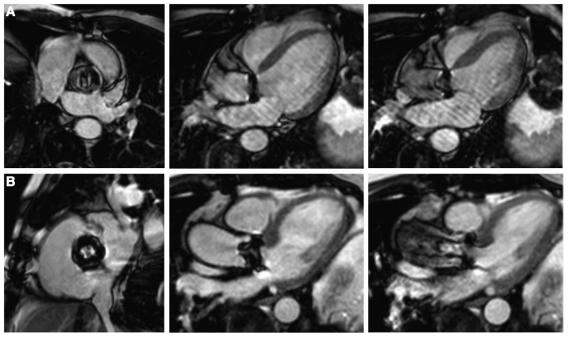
Magnetic resonance imaging in prosthetic heart valves magnetic resonance steady-state free-precession images of the mechanical carbomedics (A, top row) and biological Perimount (B; bottom row) aortic prosthetic valves in plane and perpendicular in diastole and systole, respectively.
